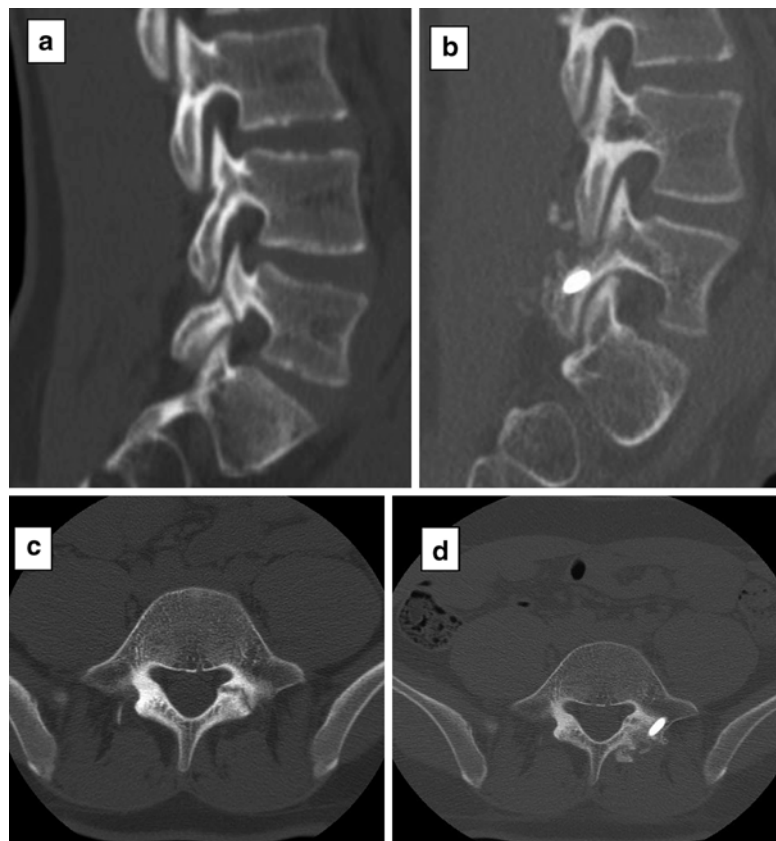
(a, b) The sagittal view of a CT scan showing pars defect before and after direct laminar/pars compression screw fixation. (c, d) Axial view of the CT scan showing left pars defect before and after surgery. Bony union is achieved
